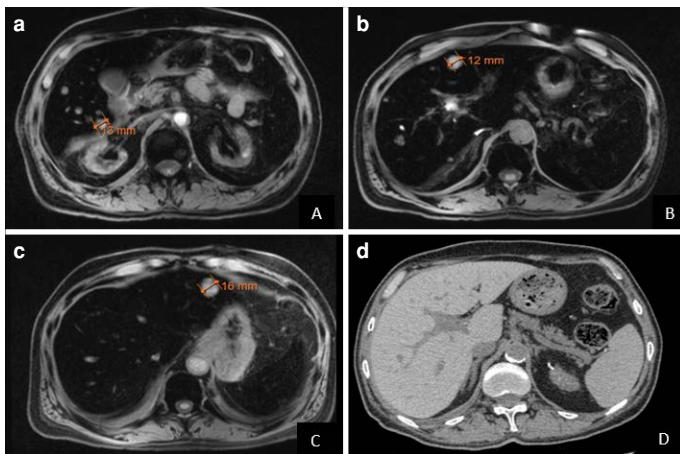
(a–c) Abdominal T2-weighted MRI showing upper abdominal segments with multiple hyperintense lesions of 12–16 mm, and diminished hepatic intensity compatible with iron overload. (d) Follow-up abdominal CT of 5 months later, showing dilated bile ducts with relatively clear parenchyma.
